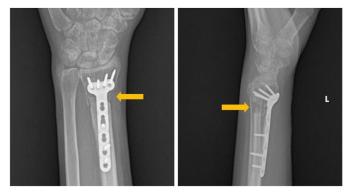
Bridging callus (yellow arrows) seen for the first time on postoperative posteroanterior and lateral radiographs at 12 weeks in all three cortices.
